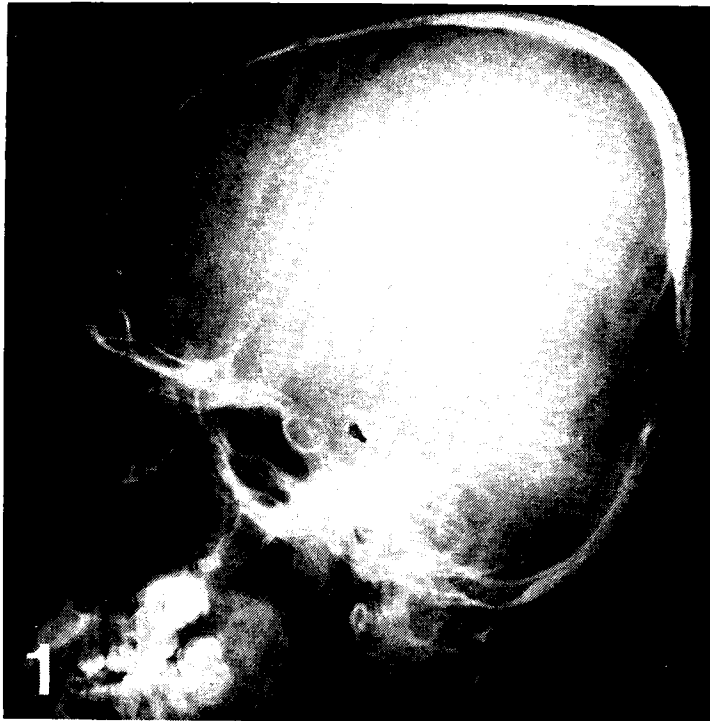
Skull lateral x-ray showing slight ballooning of the sellar floor.
